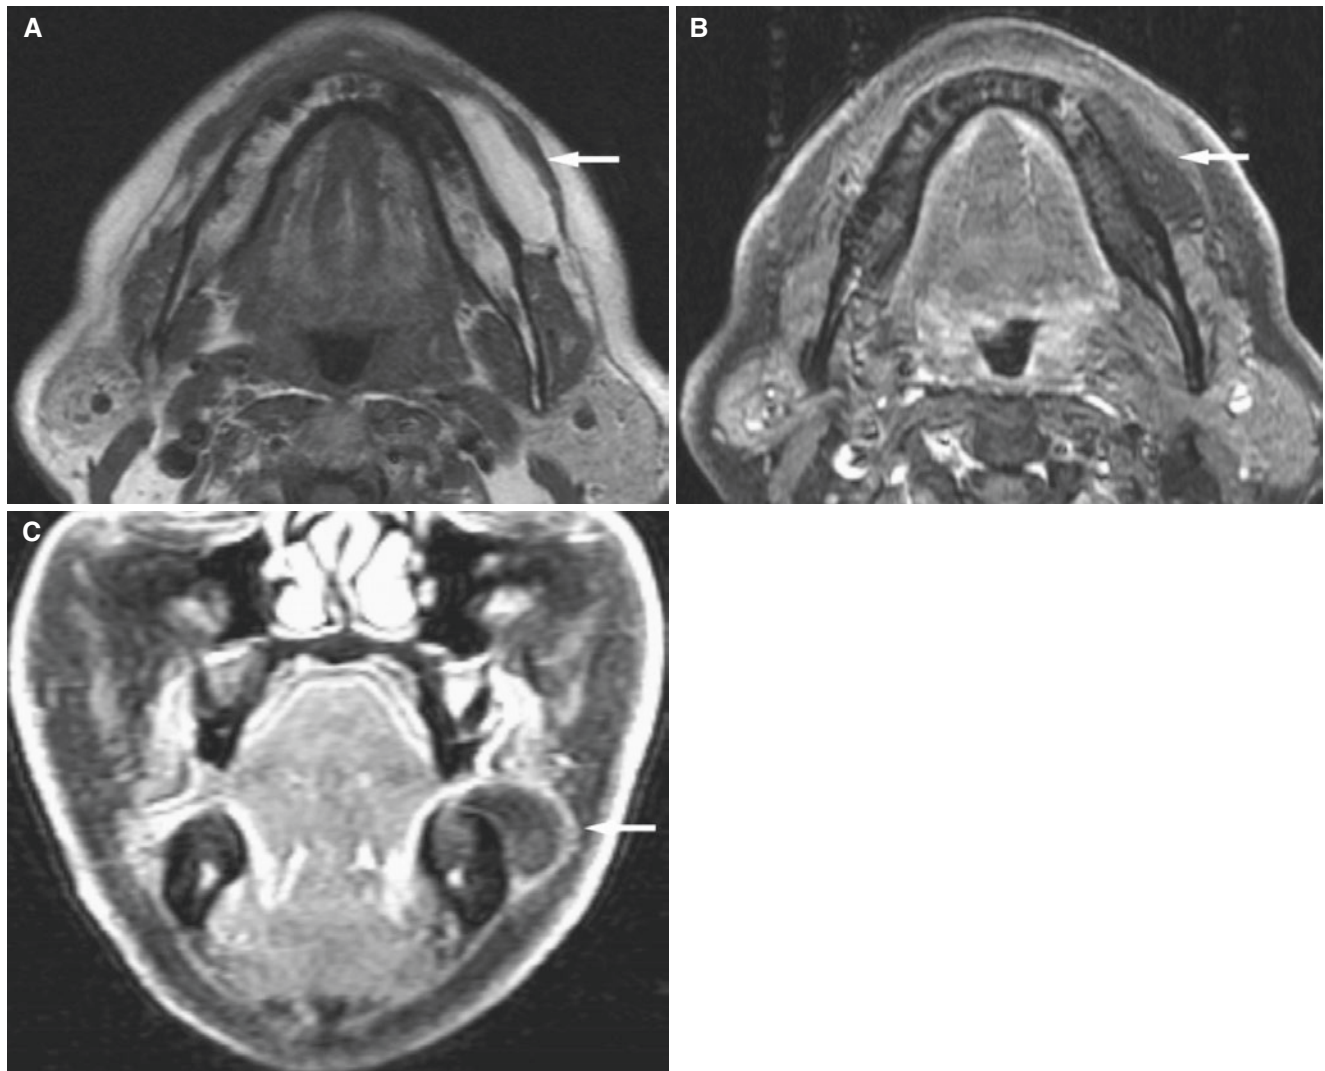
Lipoma of lower gingivobuccal sulcus; 67-year-old male with fullness of left lower gingivobuccal sulcus with clinical suspicion of being fatty. (A) Axial T1-weighted MRI shows well-defined area of homogeneous high signal along the left mandible (*arrow*). (B) Axial
